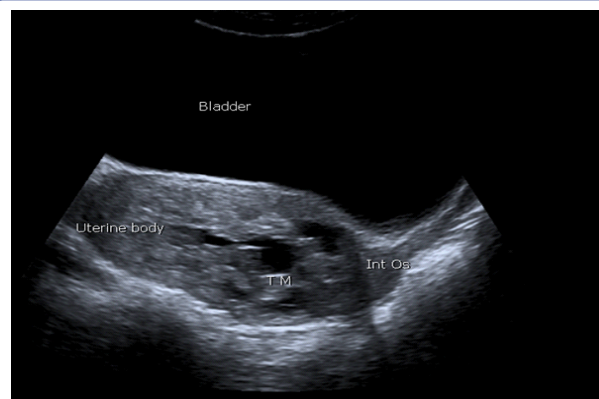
Routine 11 week Transabdominal ultrasound in Case No. 1, showing a trophoblastic mass in the isthmic region of the uterus. It does not appear to be asymmetrically placed anteriorly. The CSD itself is not visible. The upper uterine body is empty. The diagnosis of CSP was not considered and hence missed.
